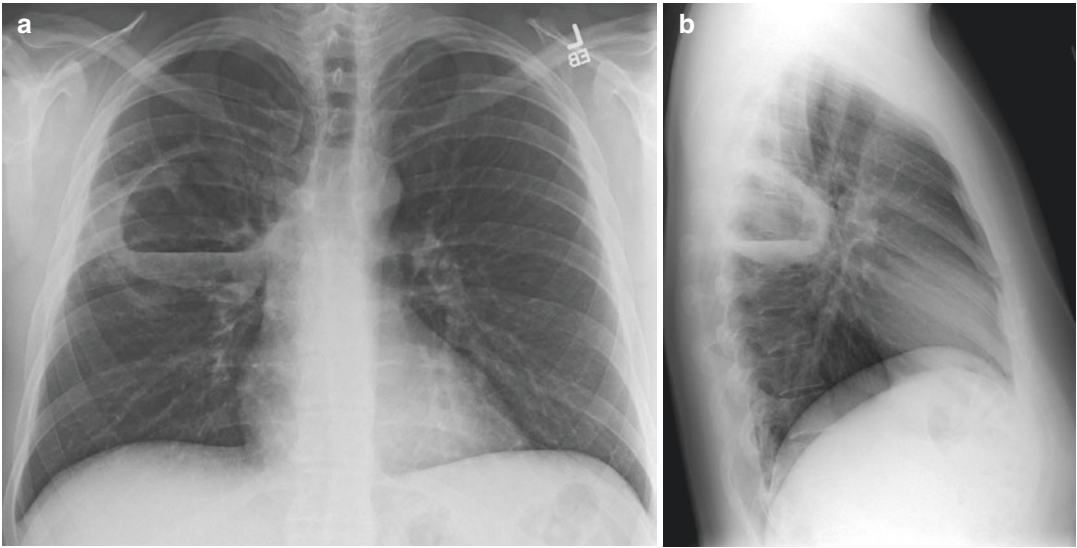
Frontal (a) and lateral (b) chest radiographs of a 28-year-old male with a 1-month history of cough found to have a pulmonary abscess, demonstrated by a localized, walled cavity, with an air-fluid level in the right lower lobe
